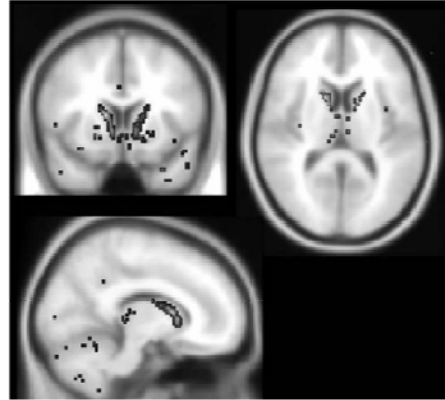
Association between impaired insight and grey matter excess displayed on MNI space template T1-weighted MRI
